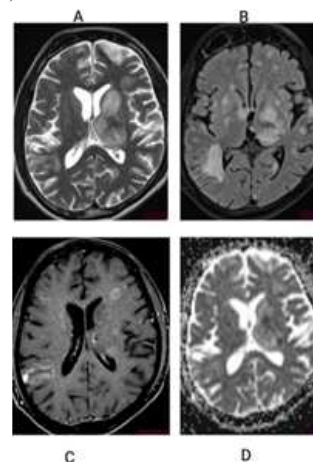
CNS Toxoplasmosis -Multiple T2/FLAIR (A&B) hyperintense abnormal signal areas noted in bilateral cerebral hemisphere predominantly along basal ganglia showing no diffusion restriction and drop on ADC(D) and showing peripheral ring enhancement on T1 post contrast study(C)
